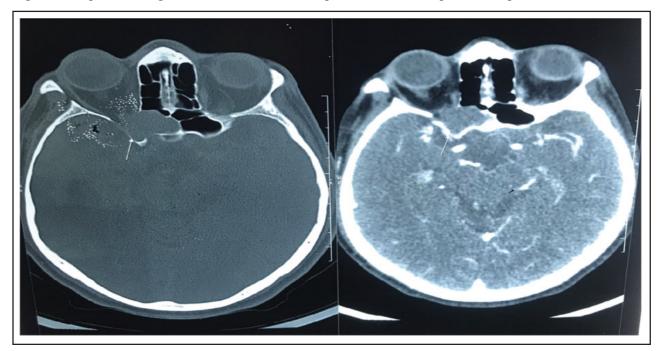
CT scan axial view shows completely opacified expanded right sided onodi cell with rarefaction of the sinus which extends into pneumatized right anterior clinoid process and encasing the right optic canal which is suggestive of mucocele compressing the right optic canal
